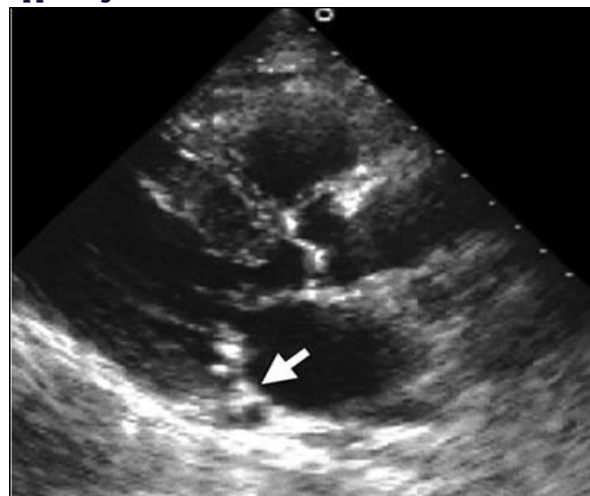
Two-dimensional Echocardiography Demonstrated Severe Mitral Stenosis with Left Atrial Enlargement and Pulmonary Hypertension.
